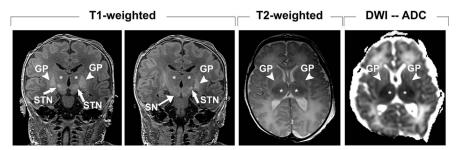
Conventional MRI performed on postnatal day 5 in an infant who went on to develop CBE. Coronal T1-weighted, axial T2-weighted, and axial-apparent diffusion coefficient (ADC) images are shown. Increased T1-signal is readily apparent in the globus pallidus (GP) and subthalamic nucleus (STN), with more subtle evidence of increased T1-signal in the substantia nigra and hippocampus (not labeled). There is also subtle increased T2-signal in the GP. Remarkably, the ADC images did not demonstrate any restricted diffusion in the GP; however, there was subtle evidence of restricted diffusion in the ventrolateral nucleus of the thalamus, posterior limb of the internal capsule, and the hippocampus (not pictured). *, thalamus; DWI-ADC, diffusion-weighted image-apparent diffusion coefficient. (From Wisnowski JL, Panigrahy A, Painter M, et al. Magnetic resonance imaging of bilirubin encephalopathy: current limitations and future promise. Semin Perinatol 2014;38:424; with permission.)
